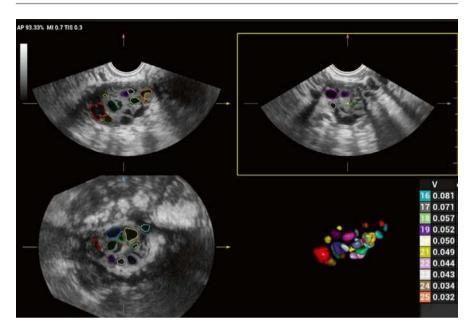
Automatic measurement of follicle counts and follicle diameters in the ovary with the Smart FLC function of a 3D ultrasonography system
